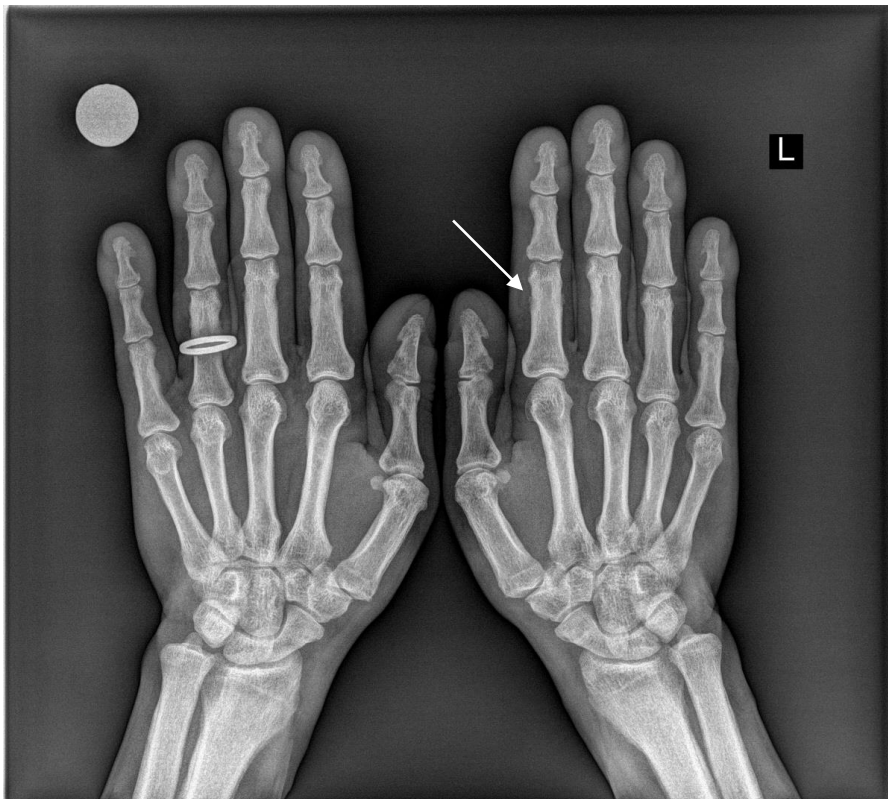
Left and right hand radiography at presentation show periosteal reaction involving middle and proximal phalanges of both hands in a fairly symmetric pattern - patient with hypertrophic osteoarthropathy
